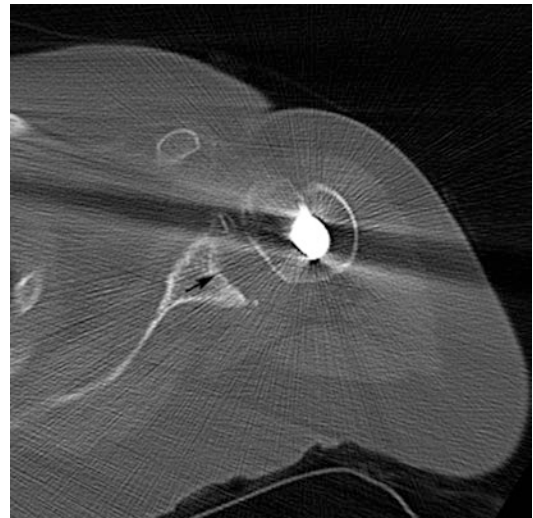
Hemiarthroplasty complication. Axial CT of the left shoulder in a patient with a hemiarthroplasty shows central glenoid erosions and remodeling
